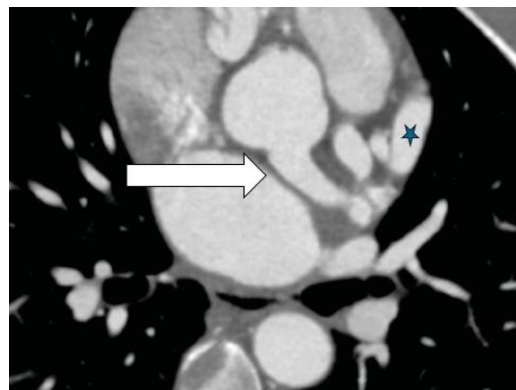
CTA axial image showing normal origin of LCA from left coronary sinus (white arrow). Dilatation and tortuosity of RCA and LAD (shown by stars)
